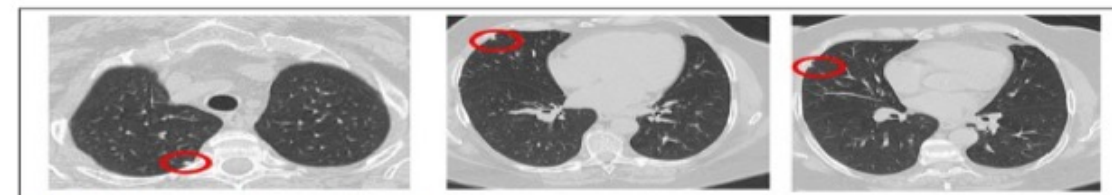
Multiple pulmonary nodules on HRCT in a patient with IVD.
